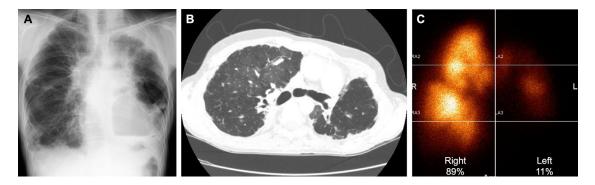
(A) Chest radiograph showing a small left thorax and large bulla in the left lower lung field. (B) Chest computed tomography before lung transplant showing patchy ground-glass lesions in the bilateral lung fields consistent with bronchiolitis obliterans after hematopoietic stem cell transplant. (C) Lung perfusion scintigraphy with technetium-99m–labeled macroaggregated albumin showing a perfusion ratio in the right lung of 89%.
